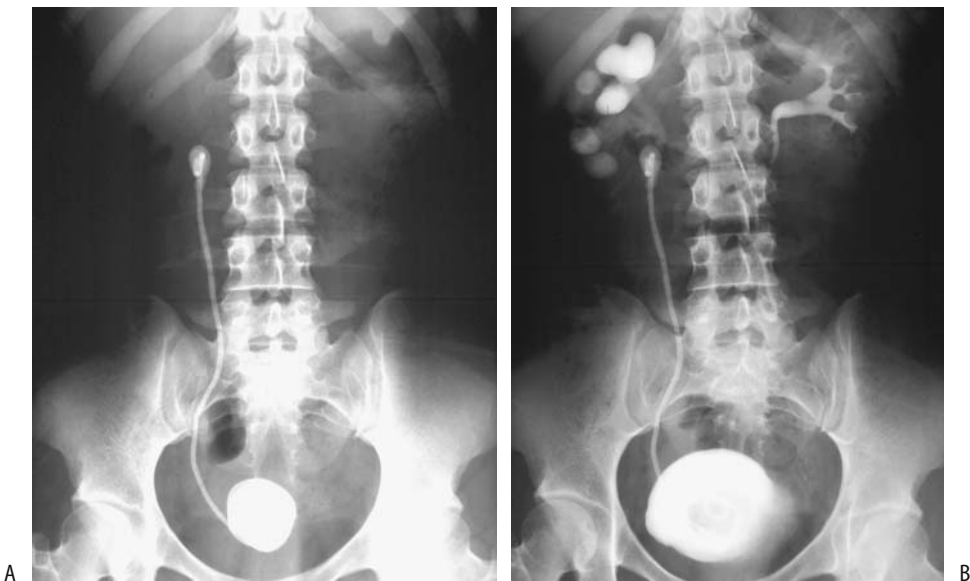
Ureteral stent encrustation. A: A conventional radiograph shows a right ureteral stent with radiopaque encrustation both proximally and distally. B: A urogram reveals ureteropelvic obstruction due to the proximal encrustation. Several cystoscopic attempts were necessary to treat the vesical encrustations. Renal encrustations were treated percutaneously and eventually the stent was successfully removed. (Source: Dyer RB, Chen MY, Zagoria RJ, Regan JD, Hood CG, Kavanagh PV. Complications of ureteral stent placement. *RadioGraphics* 2002;22:1005–1022, with permission from the Radiological Society of North America.)
